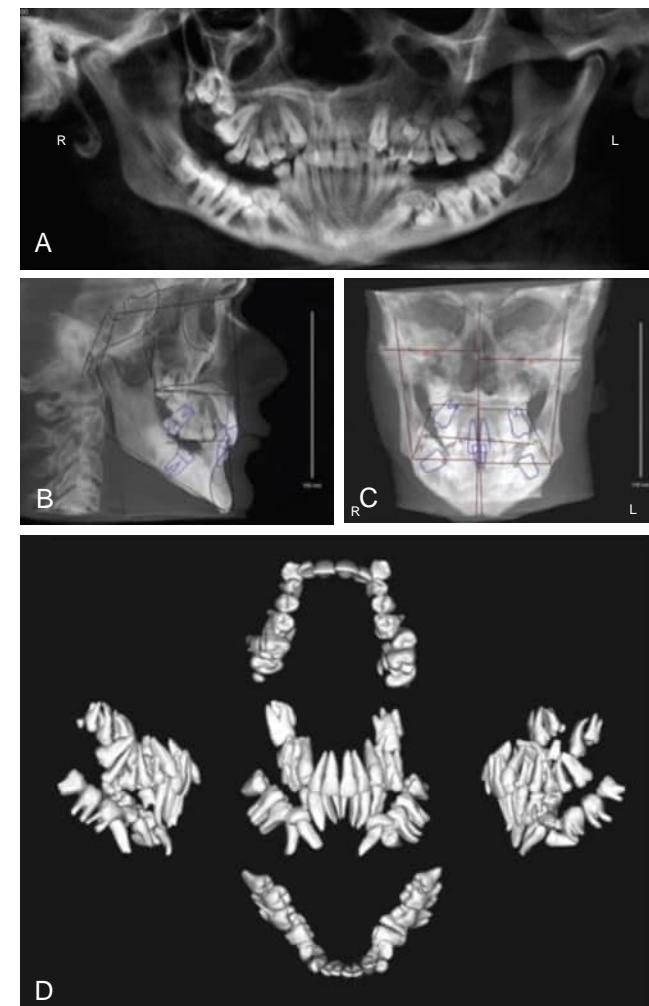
A 17-year-old Caucasian male diagnosed with trichorhinophalangeal syndrome, type I. (A) Panoramic radiograph showing multiple retained supernumerary and impacted teeth with long, well-developed root structure in both maxillary and mandibular arches. (B and C) Lateral and posteroanterior cephalograms showing prominent chin button, mild class II skeletal relationship, lingually inclined maxillary and mandibular incisors, steeply inclined lower border of the mandible, obtuse gonial angle, and shortened posterior facial height with short mandibular ramus. (D) Virtual models showing development of roots and multiple impacted teeth. (Reprinted from Journal of Orthodontics, Volume 40, Issue 1, pages 47-52, by Ahmed Ghoneima, Kanwar Sachdeva, James Hartsfield, David Weaver & Katherine Kula, The use of cone beam computed tomography for the assessment of trichorhinophalangeal syndrome, type I – a case report (Copyright 2013) with permission from Sage Publisher.)
